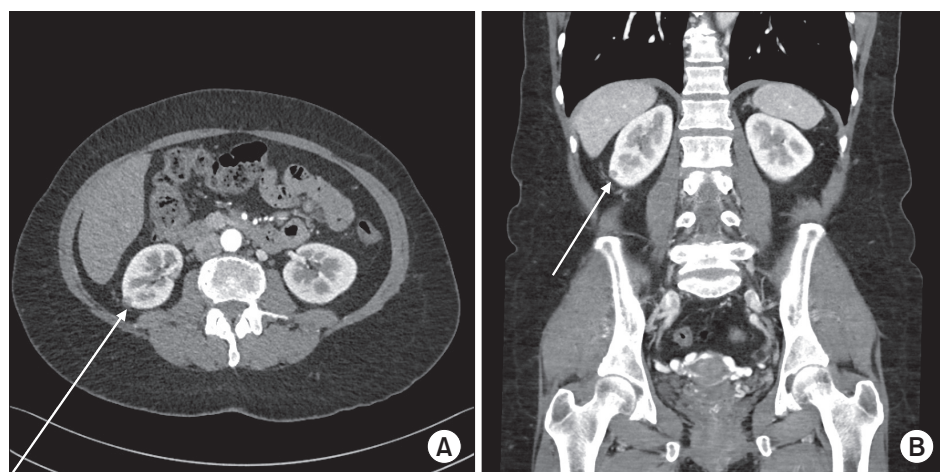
(A) Transverse abdominal computed tomography angiogram of the 44-year-old kidney donor shows 0.9 cm tumor in the mid pole of the right kidney (arrow). (B) Coronal abdominal computed tomography angiogram of the 56-year-old kidney donor shows 0.7 cm tumor in the lower pole of the right kidney (arrow).
